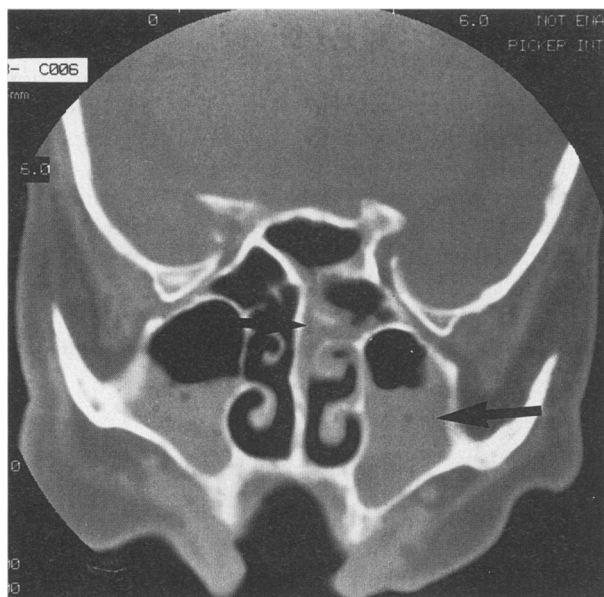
A computed tomographic scan shows mucosal thickening and an air-fluid level in the left maxillary sinus (lower arrow) and mucosal thickening in the left ethmoid sinus (upper arrow) and left middle turbinate compared with normal turbinates on the opposite side.
